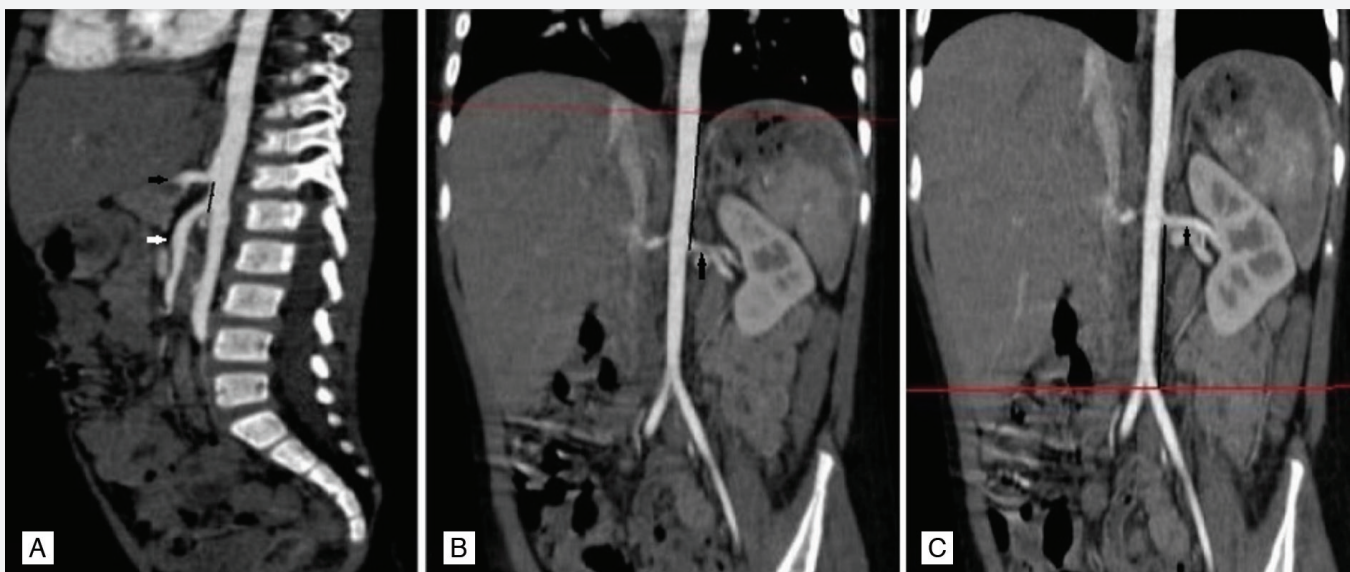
Computed tomography angiography of the abdominal aorta of a 4-year-old male patient. The oblique sagittal image demonstrates the distance measurement between the celiac trunk (black arrow) and superior mesenteric artery (white arrow) (A). The oblique coronal image shows the distance measurement between the left renal artery (black arrow) and the line that represents the aorta at the diaphragmatic region (B). The oblique coronal image demonstrates the distance measurement between the left renal artery (black arrow) and the line that represents the aortic bifurcation level (C)
